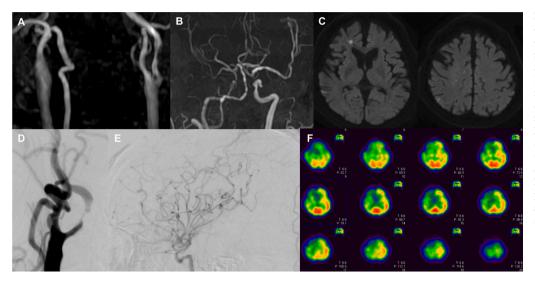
(A, B) Magnetic resonance angiography performed on admission, demonstrating poor visualization of the right internal carotid artery (ICA) and moderate stenosis at the origin of the left ICA. (C) Diffusion-weighted magnetic resonance imaging performed on admission, showing multiple acute cerebral infarcts in the right cerebral hemisphere. (D, E) Preoperative cerebral angiography showing severe stenosis at the origin of the right ICA and delayed antegrade flow to the right cerebral hemisphere. (F) Preoperative singlephoton emission computed tomography scan showing reduced cerebral blood flow in the right hemisphere.
